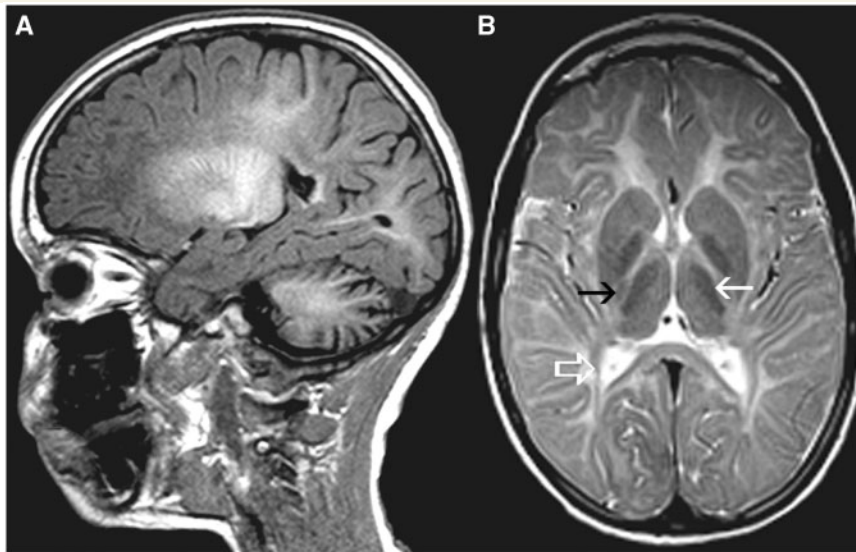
MRI of a 6-year-old male with 4H syndrome. The sagittal T₁-weighted image shows cerebellar atrophy (A). The axial T₂-weighted image (B) shows relatively lower signal of the anterolateral part of the thalamus (white arrow), pyramidal tract at the level of the posterior limb of the internal capsule (black arrow) and the optic radiation (white open arrow).
